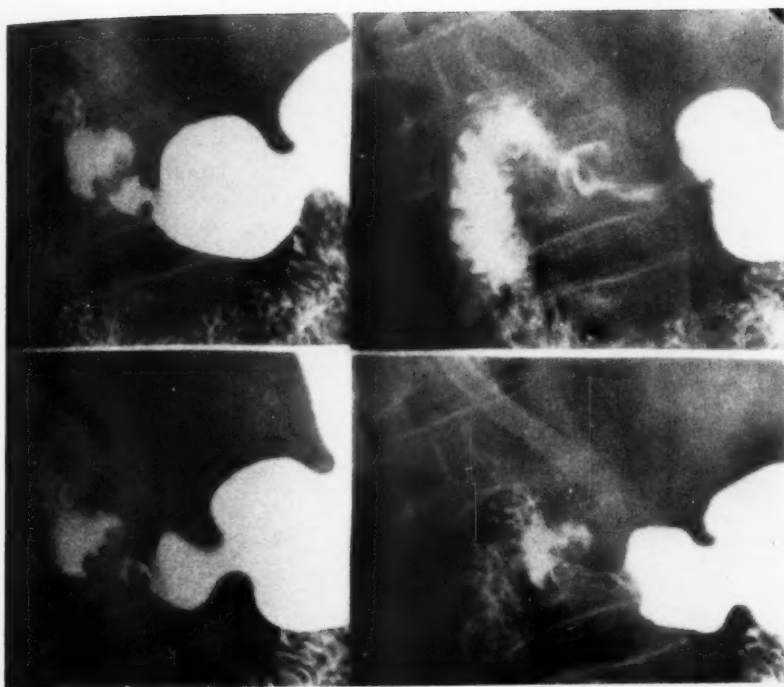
Serial x-ray views showing diaphragm in antral portion of stomach and prolapse of "prepyloric" mucosa into the duodenum. Prolapse is seen when the "compartment" is contracted.
